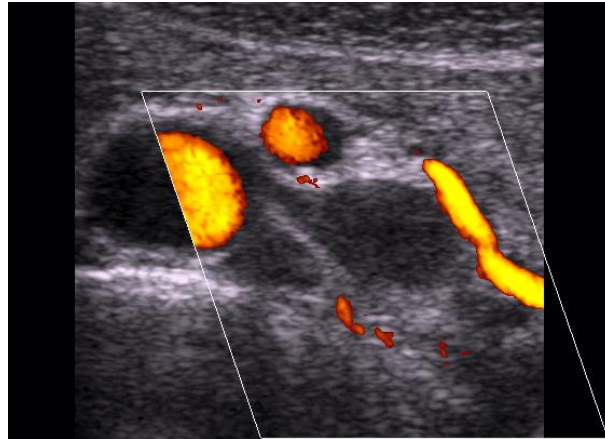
Nutcracker syndrome. B-mode (a) and Power Doppler (b). The left renal vein (VRS) is between the aorta (19) and superior mesenteric artery (AMS). The vertebral spine is also indicated (WS). VCI: inferior vena cava. Niere: kidney.
